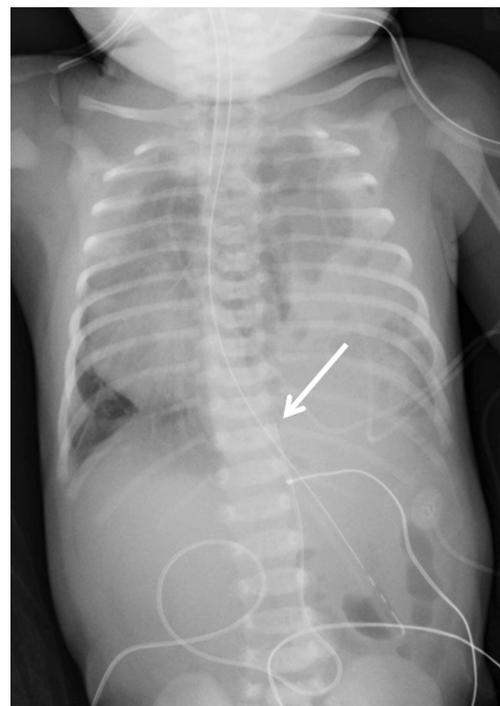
Anteroposterior radiograph of the chest and abdomen in a newborn girl shows intrahepatic placement of the UVC (umbilical venous catheter) (arrow)
